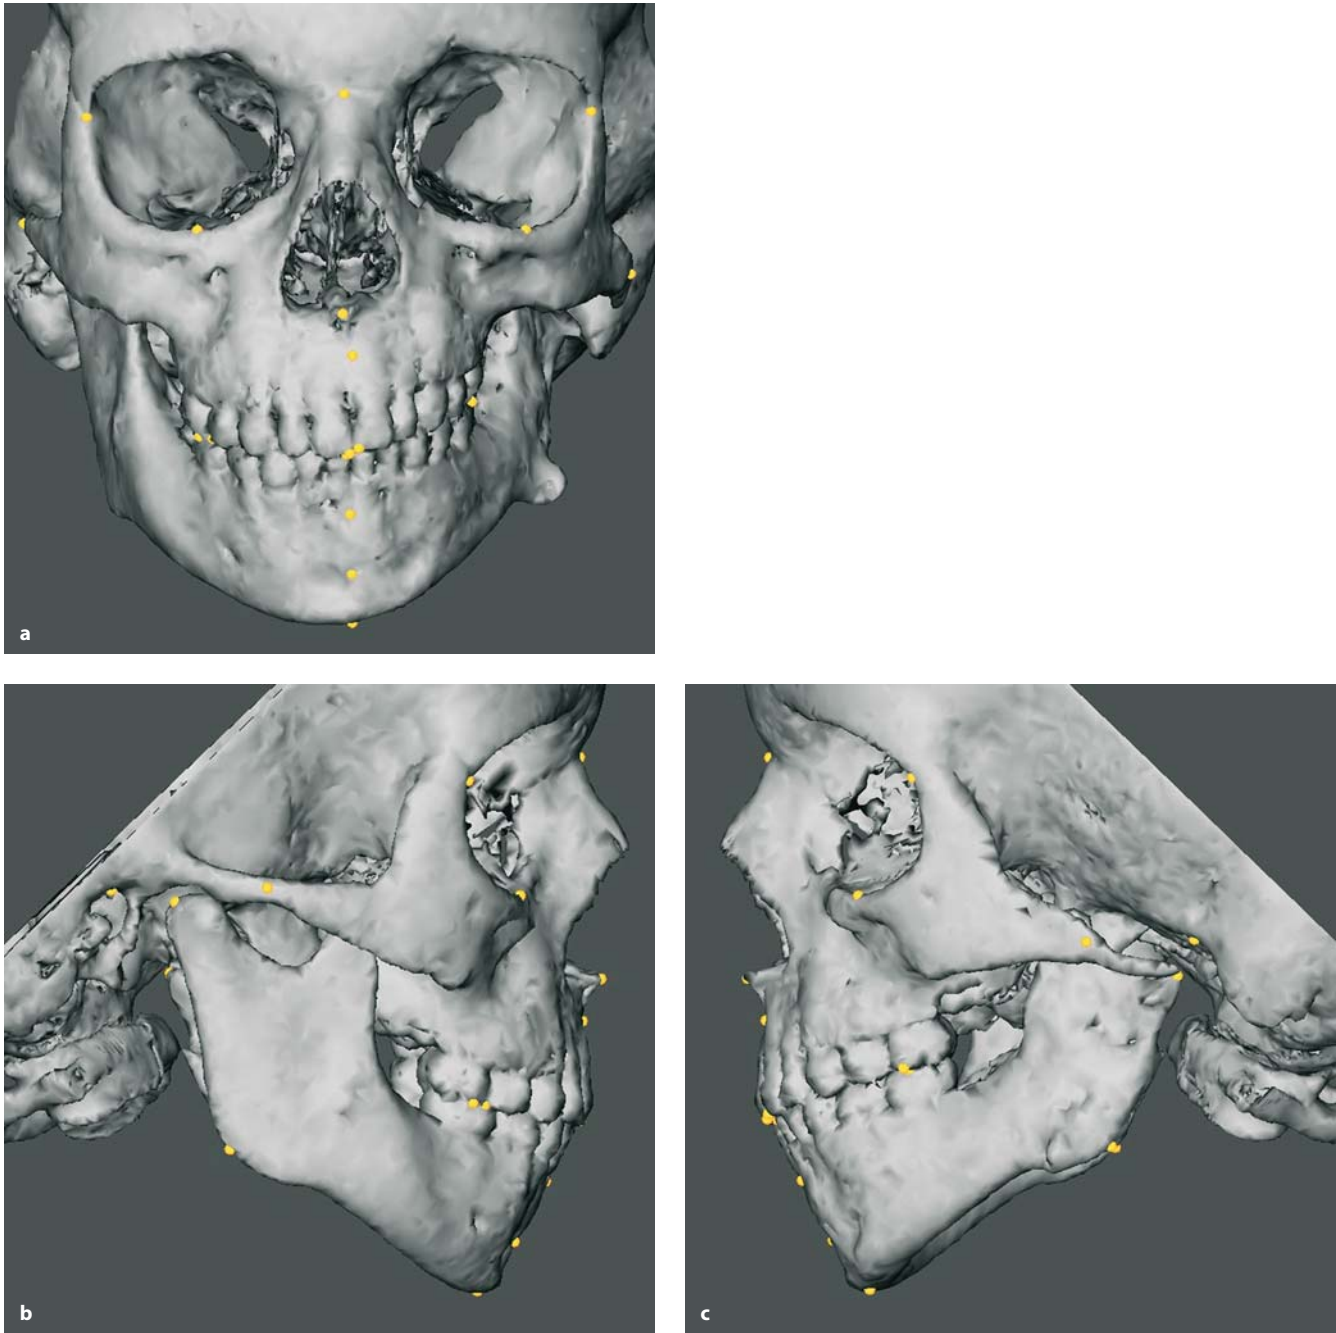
Post-distraction 3-D CT hard tissue surface representations with set-up of 3-D cephalometric hard tissue landmarks. Note uprighting of the left mandibular vertical ramus with good morphology of the left gonial angle. a Frontal view; b profile view right; c profile view left. (3-D CT, patient H.T.)
